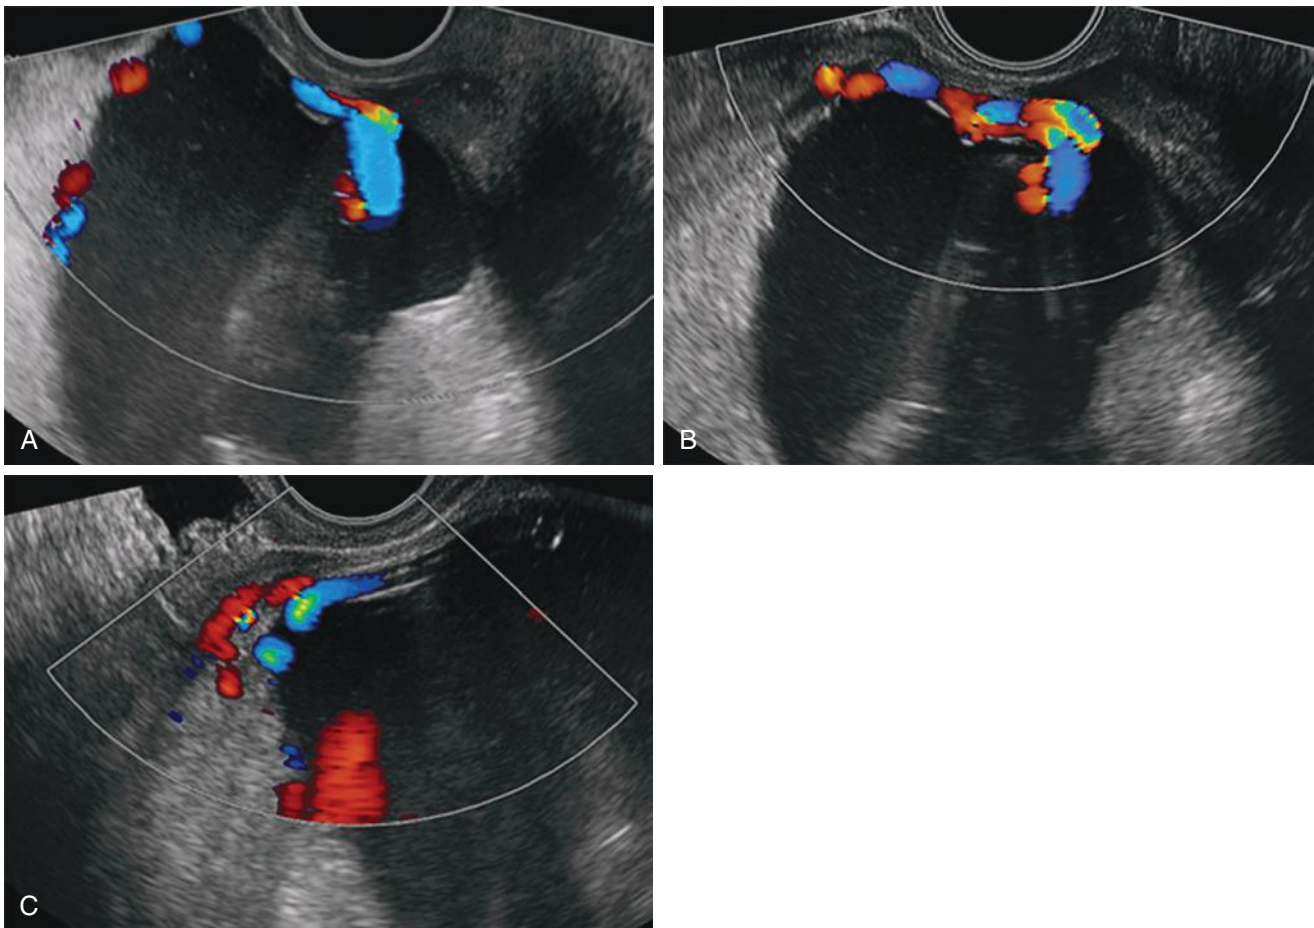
Velamentous cord insertion. A, In this transvaginal color Doppler ultrasound image at 22 weeks' gestation, the umbilical cord is seen inserting into the membranes along the anterior wall of the lower uterine segment, a short distance away from the anterior placenta. B, The umbilical vessels run along the anterior uterine wall. C, The umbilical vessels insert into the inferior margin of the anterior placenta.
